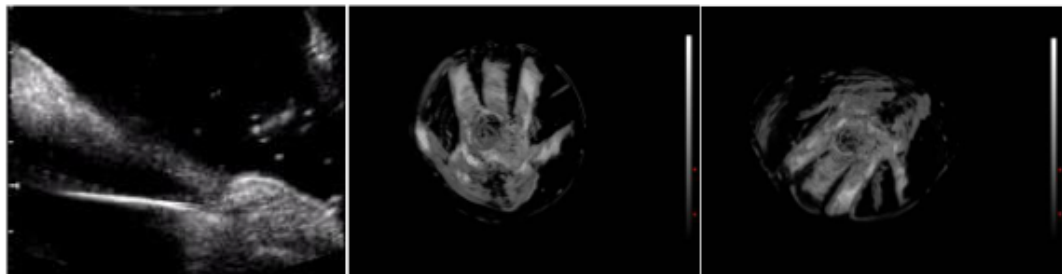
Ultrasound vertical radial slice (left); Ultrasound 3D reconstructions of the hand scan with palm view (middle) and back/wrist view (right).
